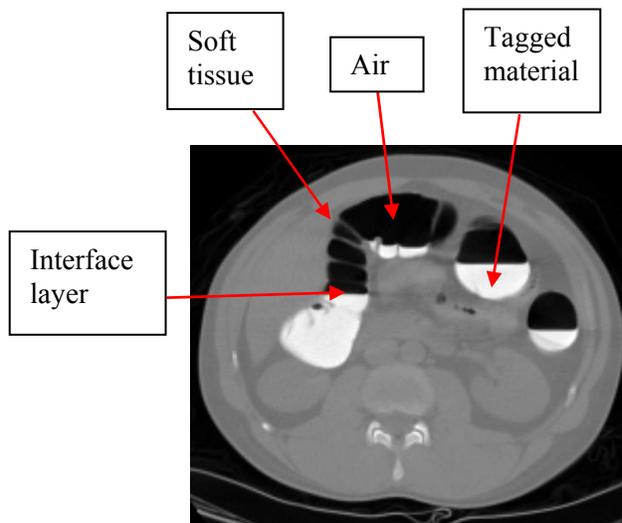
shows one transverse slice of CT images.
